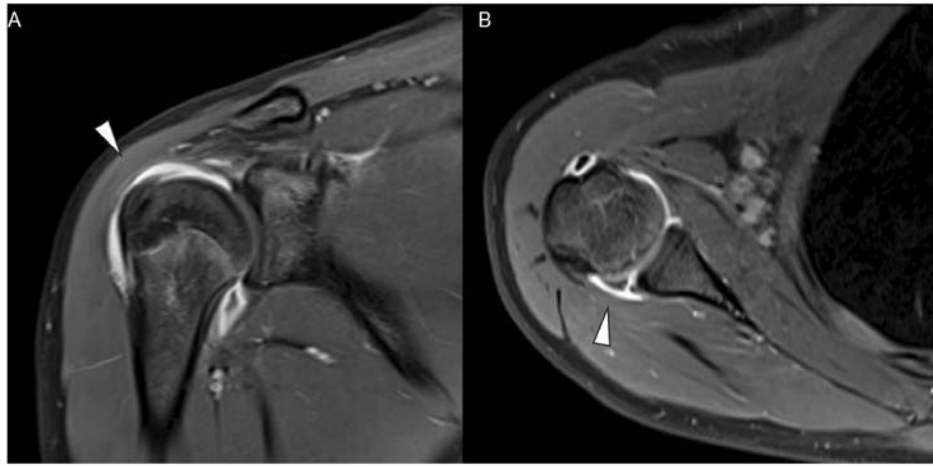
Right shoulder magnetic resonance imaging. Right shoulder contrast-enhanced, fat-suppressed, T1-weighted magnetic resonance imaging revealing synovial hypertrophy, joint effusion, and contrast enhancement, suggesting active synovitis (white arrow). (A) Coronal; (B) Axial.
